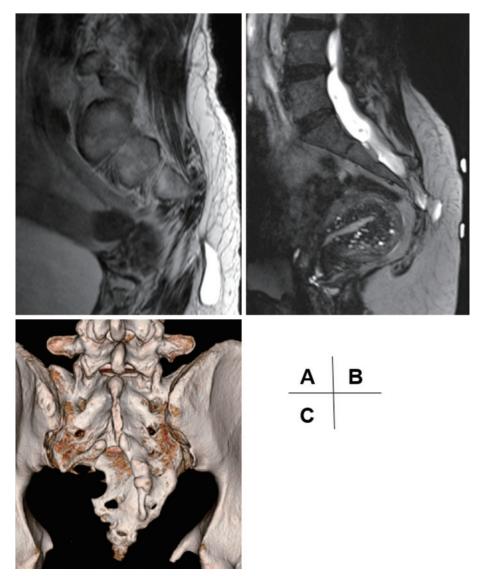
A: Sagittal lumbosacral magnetic resonance imaging T2-weighted image showing a homogeneous, high-signal subcutaneous mass of 4 cm in diameter in the left upper gluteal cleft. The anteroposterior diameter of the mass appeared smaller than that measured with palpation, probably due to the patient being supine. B: The mass is contiguous from the dural sac of the sacral spine without any internal neural tissues, suggesting a diagnosis of meningocele. C: Three-dimensional computed tomography scan of the pelvis showing a defect of the left vertebral arch at the S4 and S5 levels and slight rightward deviation of the vertebral body.
